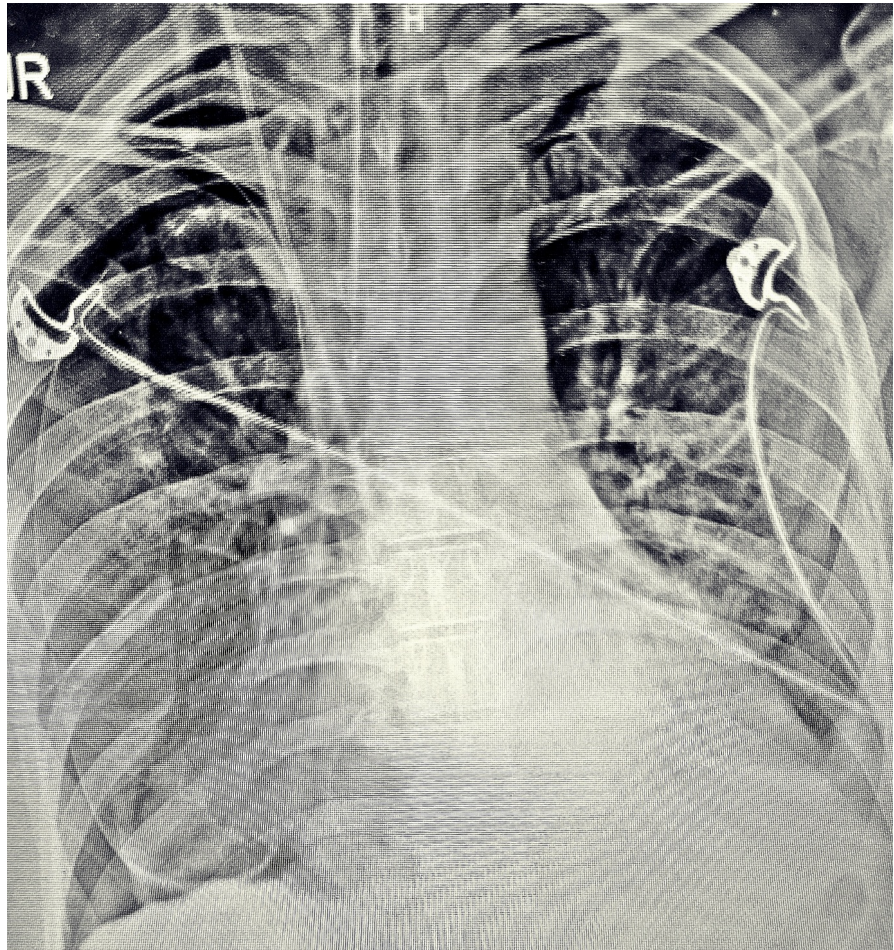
Repeat chest radiograph showing adequately positioned endotracheal tube, right internal jugular central venous catheter, and right-sided intercostal pleural drain. Expansion of the right lung has begun, with persistence of marginal pneumothorax.
